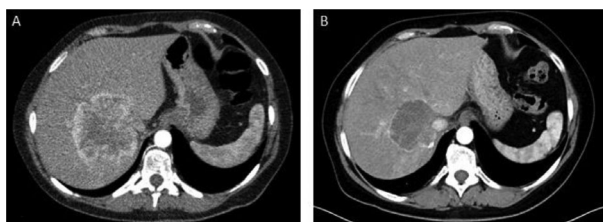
CT imaging A) At diagnosis B) After chemotherapy and transhepatic radioembolization
